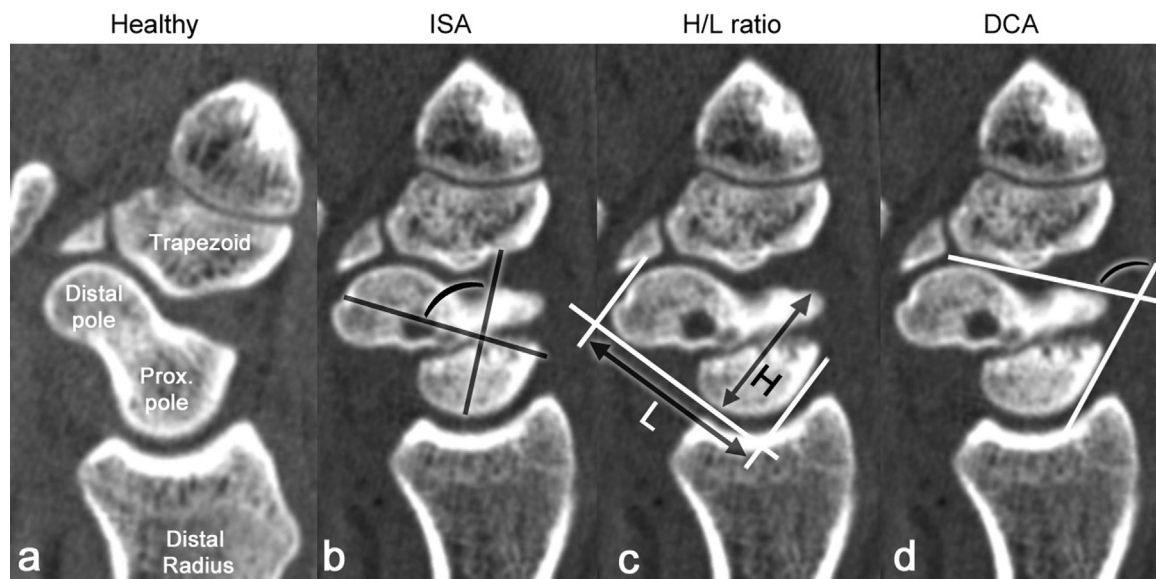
Sagittal CT slices of both wrists of a patient with a unilateral scaphoid waist nonunion (a) healthy intact scaphoid. (b), (c), and (d) scaphoid nonunion showing a typical humpback deformity as evaluated with standard CT measures [12], including (b) Intrascaphoid angle (ISA); the angle between the two lines perpendicular to the proximal and distal articular surface of the scaphoid nonunion, (c) Height-to-length (H/L) ratio; the ratio between the height of the scaphoid as measured from a palmar baseline to the dorsal humpback, and the length along the palmar baseline limited by the most proximal and distal aspects of the scaphoid, and (d) Dorsal cortical angle (DCA); the angle between two lines along the dorsal cortex of the proximal and distal fragments.
